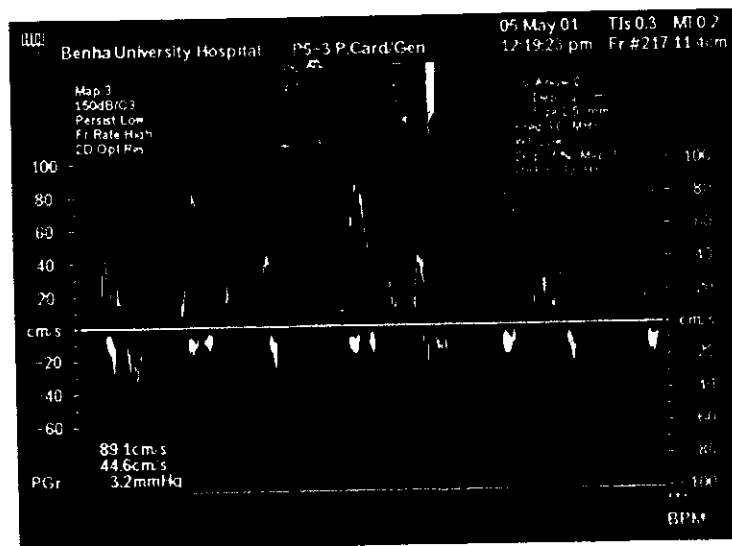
Mitral flow by pulsed Doppler. It shows normal E/A ratio.
